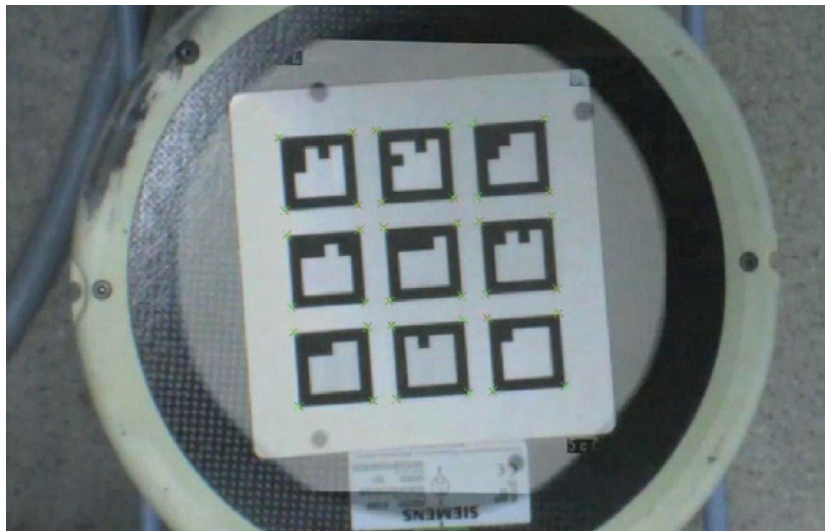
The corners of each square marker in the pattern are extracted in both X-ray and video image of the overlay. Red and Green crosses indicate the detected corners in the X-ray and video image respectively.
